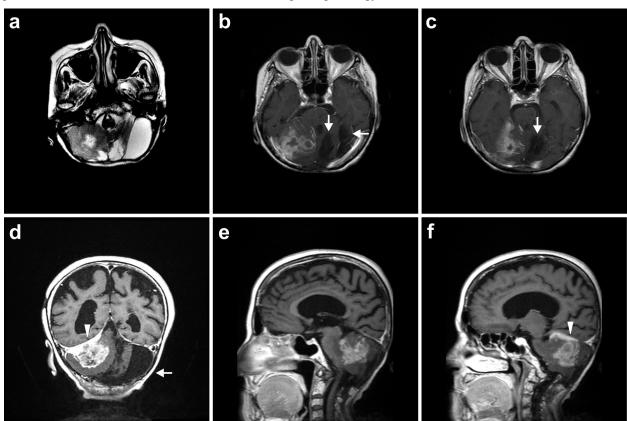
MRI data indicated a tumor in the right cerebellar hemisphere, non-homogenous T2 hyperintense (a), non-homogenous T1 hypointense (b-f), with intense gadophylia and involvement of the tentorium cerebelli (arrowheads). The tumor was infiltrative, with necrotic inner areas. Besides general telencephalic cortical atrophy, there were also two scar-like cystic areas in the left cerebellar hemisphere, probably following the previous surgical intervention (arrows).
